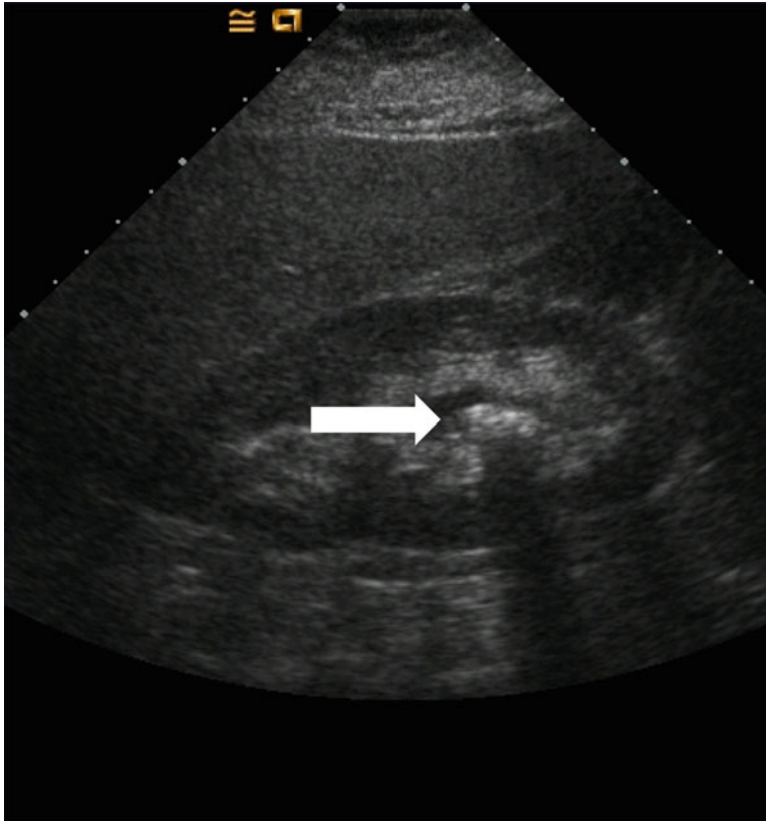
Ultrasound (US) of right kidney showing stone in lower pole (*arrow*) with posterior acoustic shadowing
